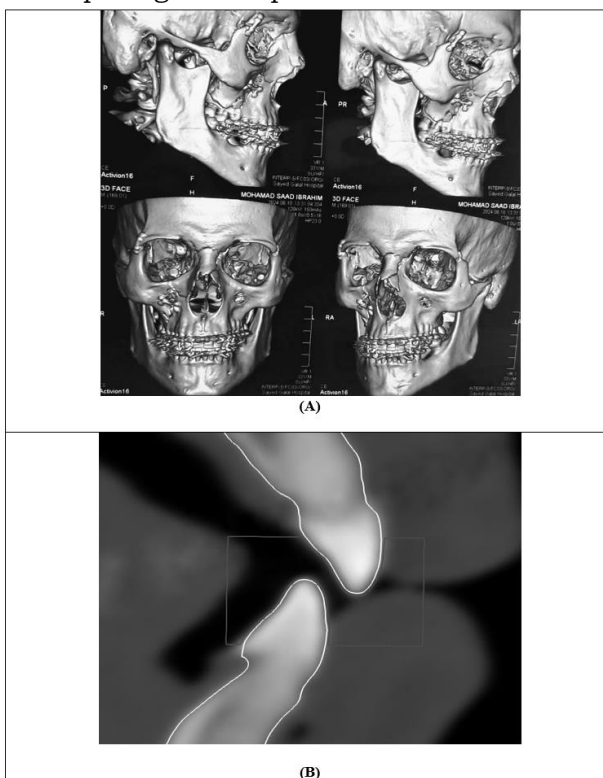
(A) postoperative CT 3D 1 month postoperative (B) Measurement of overjet and overbite
